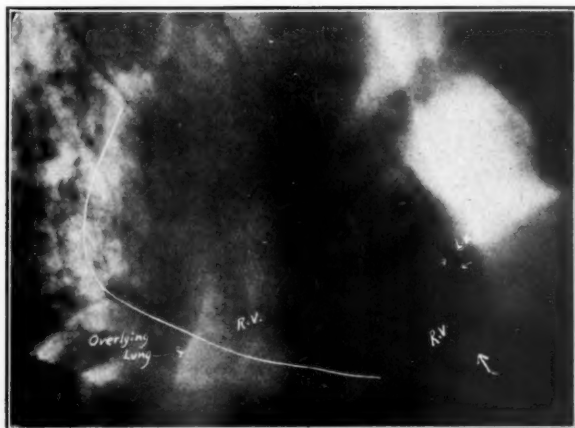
Heart-lung-liver preparation. Case of right ventricular enlargement, following chronic pulmonary fibrosis. Radiographed in left anterior oblique position with barium mixture in the interventricular groove. Note marked lower width of heart and position of interventricular groove.
